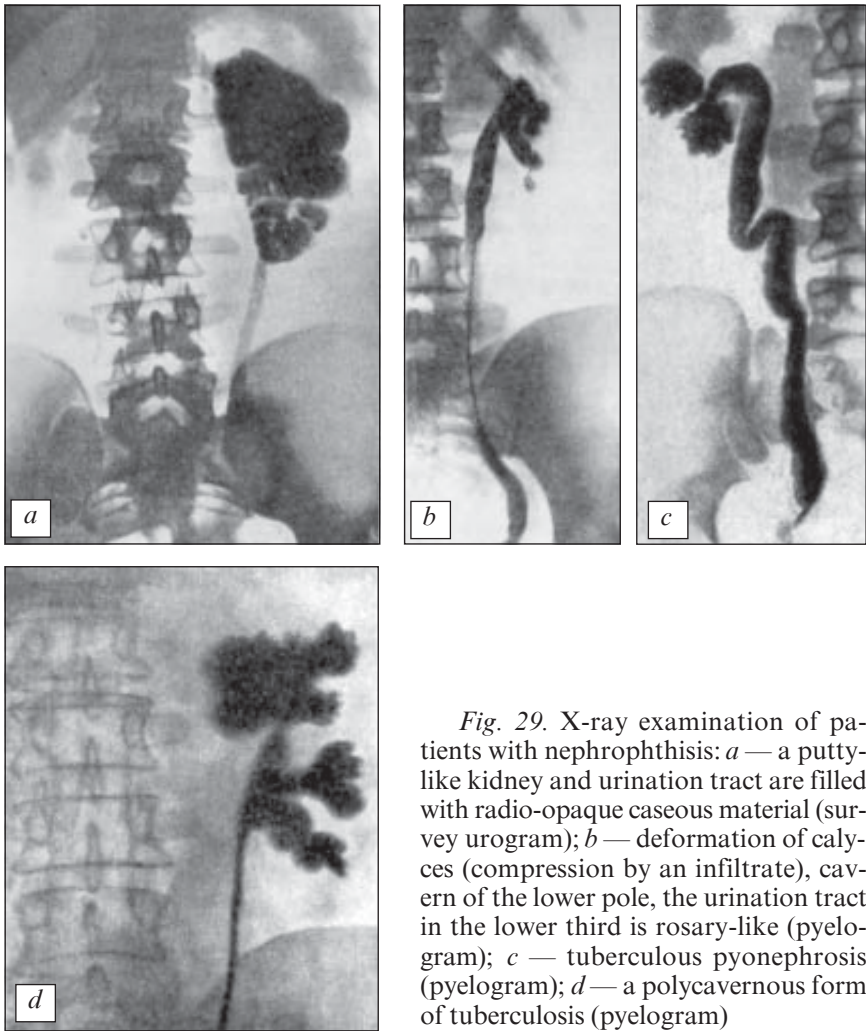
X-ray examination of patients with nephrophthisis: *a* — a putty-like kidney and urination tract are filled with radio-opaque caseous material (survey urogram); *b* — deformation of calyces (compression by an infiltrate), cavern of the lower pole, the urination tract in the lower third is rosary-like (pyelogram); *c* — tuberculous pyonephrosis (pyelogram); *d* — a polycavernous form of tuberculosis (pyelogram)
